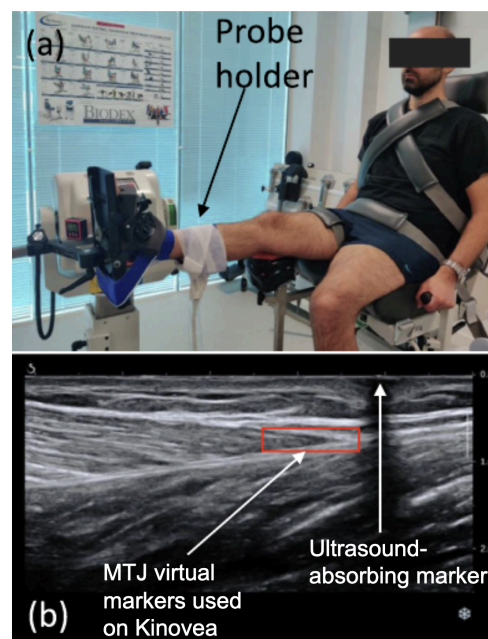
Figure (Mifsud et al., 2023) of measurement apparatus and ultrasonic landmarking.
